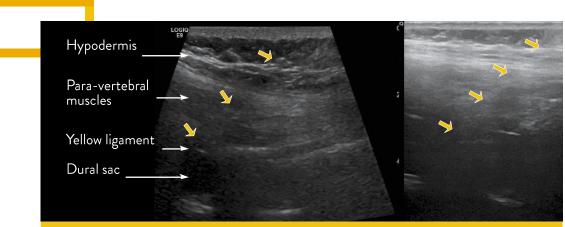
Examples of lumbar punctures under ultrasound control in longitudinal section in two different patients. The arrows indicate the needle is difficult to visualise due to the obliqueness of the puncture path.
